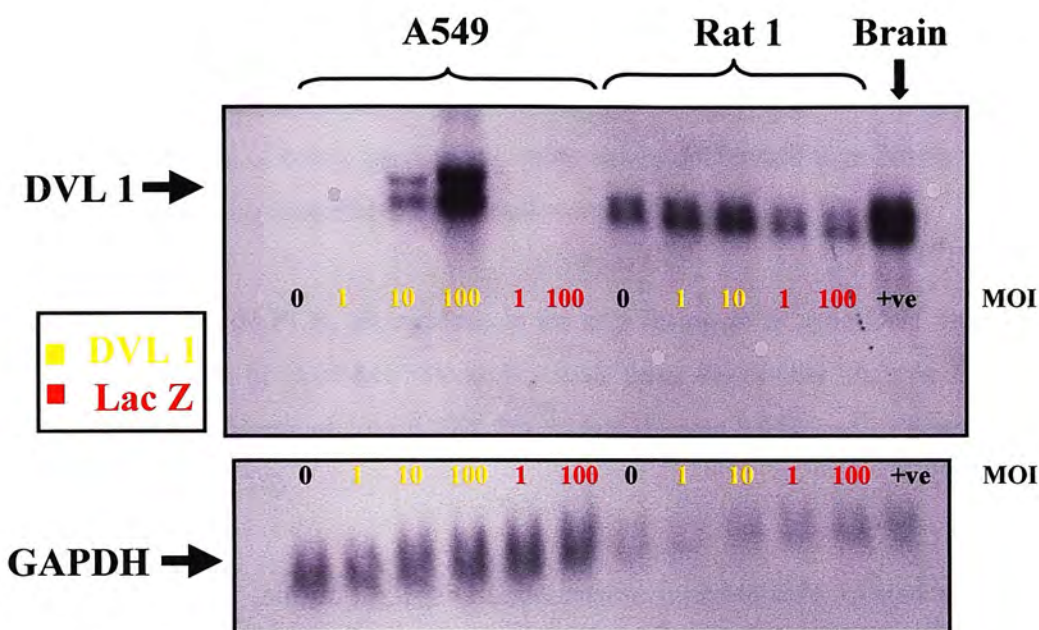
Northern 2 of Ad5-MCMV-Dvl1 *in vitro*: radiographs
